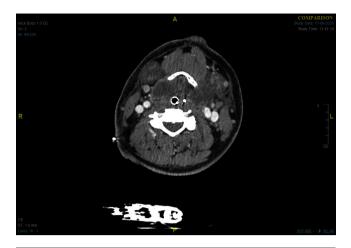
Computed tomography (CT) of the neck with contrast, axial plane, performed on the day of presentation, revealing extensive supraglottic inflammatory changes but no sign of drainable abscess.
